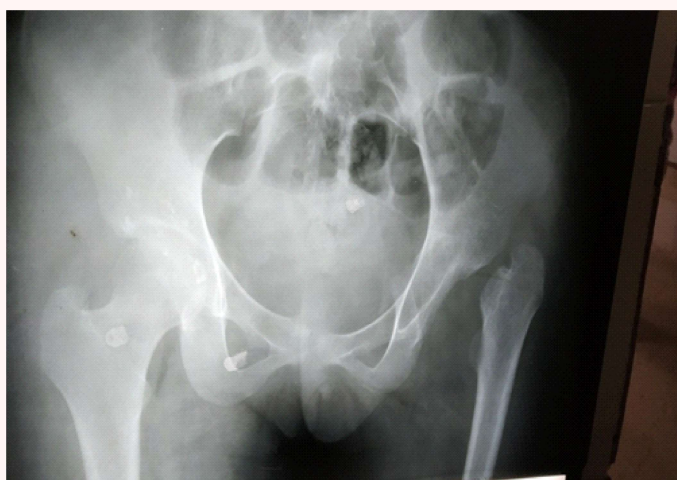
X-ray of the pelvis with both hip after the first operation, showing post-Girdlestone osteotomy and skeletal traction
